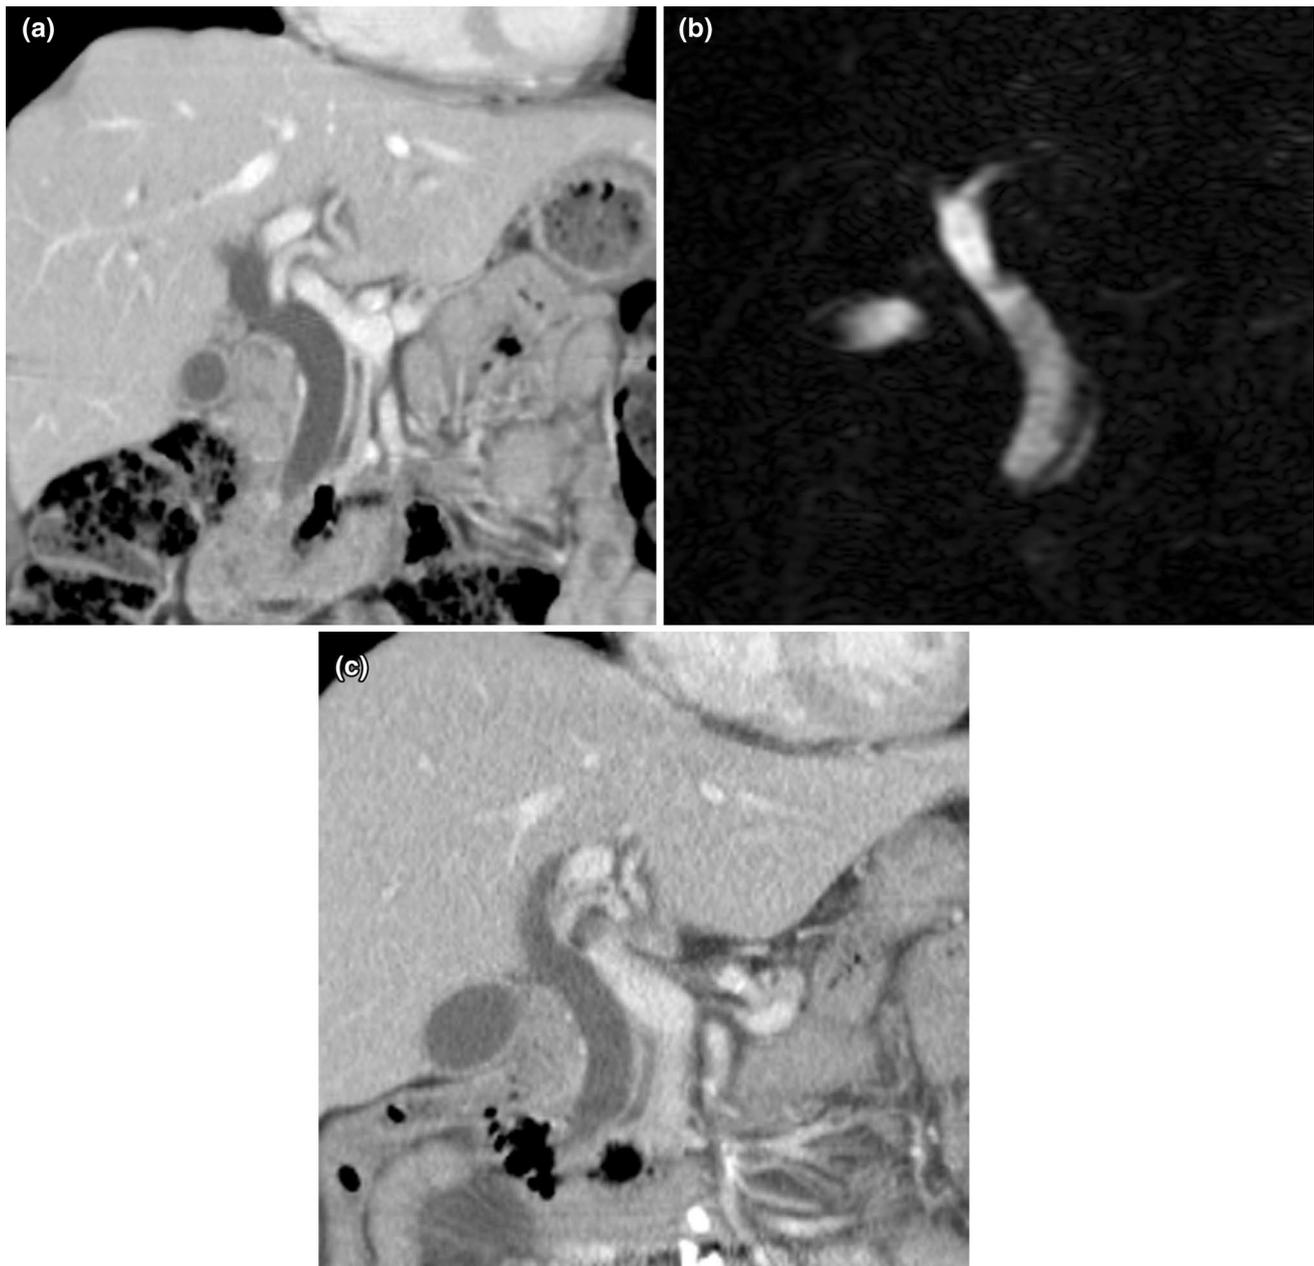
A 70-year-old female with incidental intrahepatic and extra-hepatic biliary ductal dilatation. a Coronal image from index contrast-enhanced CT shows intra- and extra-hepatic biliary dilatation without identifiable source. Follow-up coronal T2-weighted MRCP
